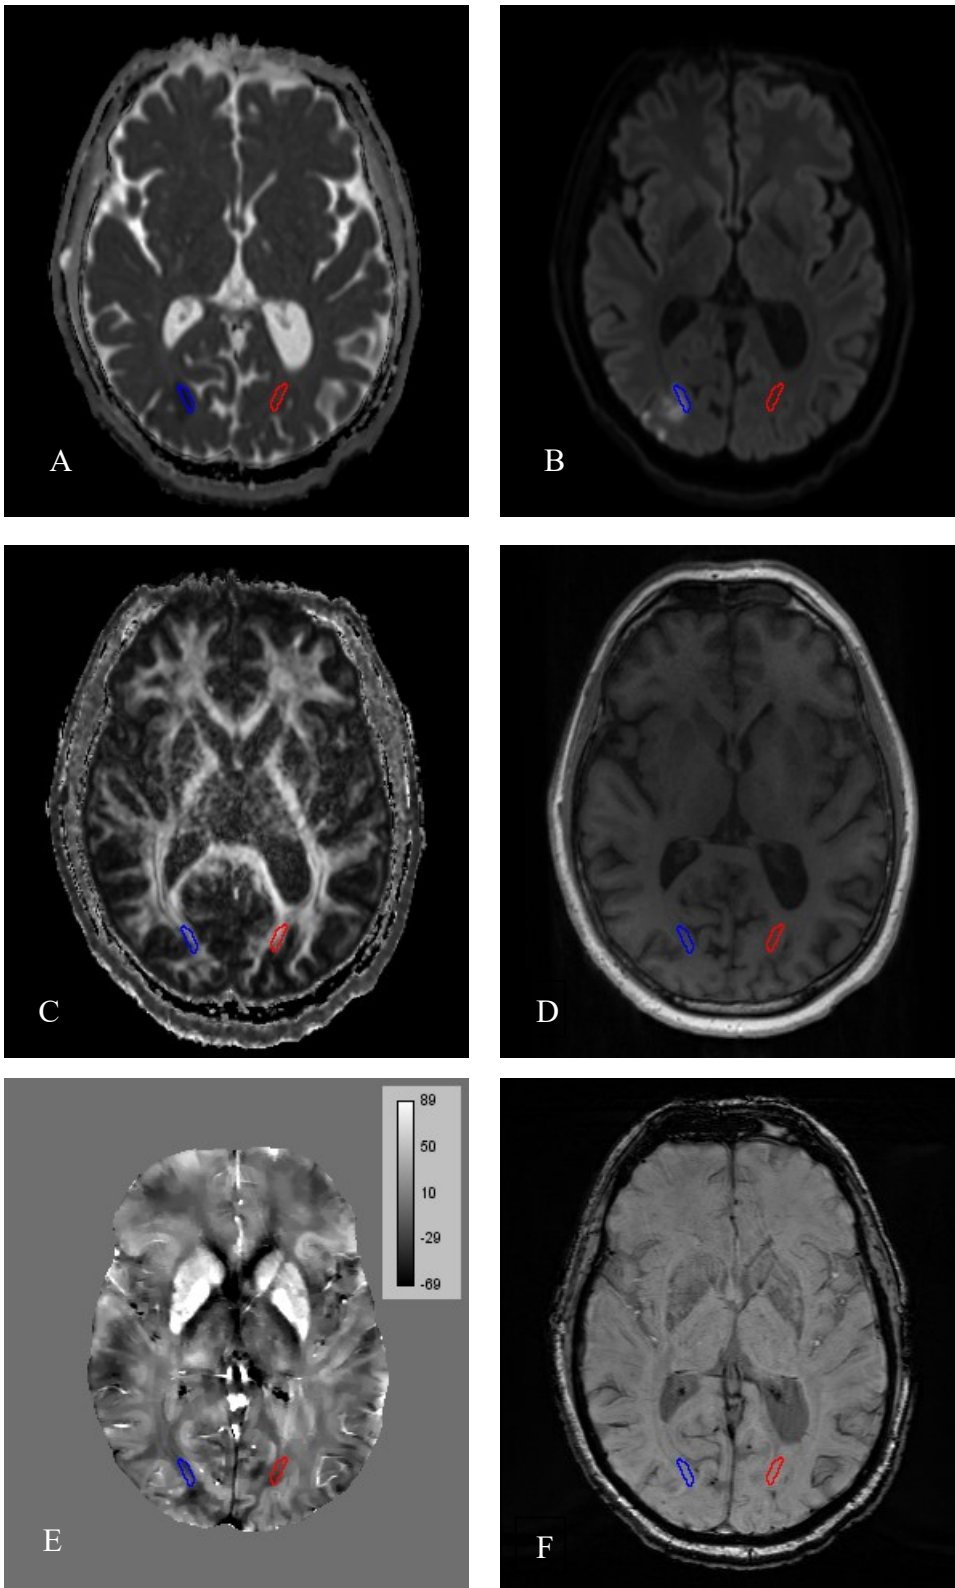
White matter tissue ROI on MD map (A), DWI (B), FA map (C), MPRAGE (D), QSM in ppb (E), SWI (F). Size of the lesion was 35.45 mm². Blue ROI is from infarcted region and red ROI is from the contralateral homologous region.
